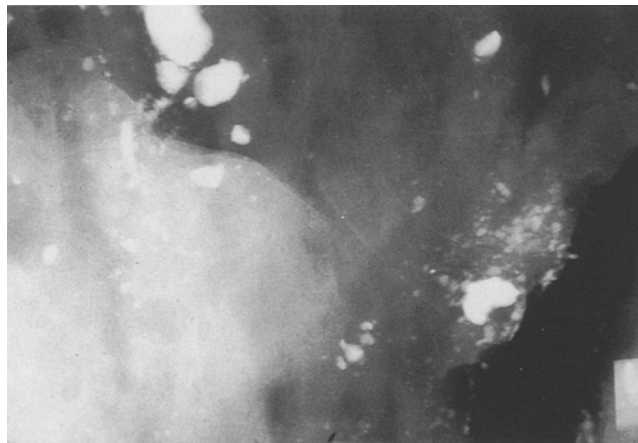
Particle of red brick in a wound caused by blunt force (18 × direct X-ray magnification)
